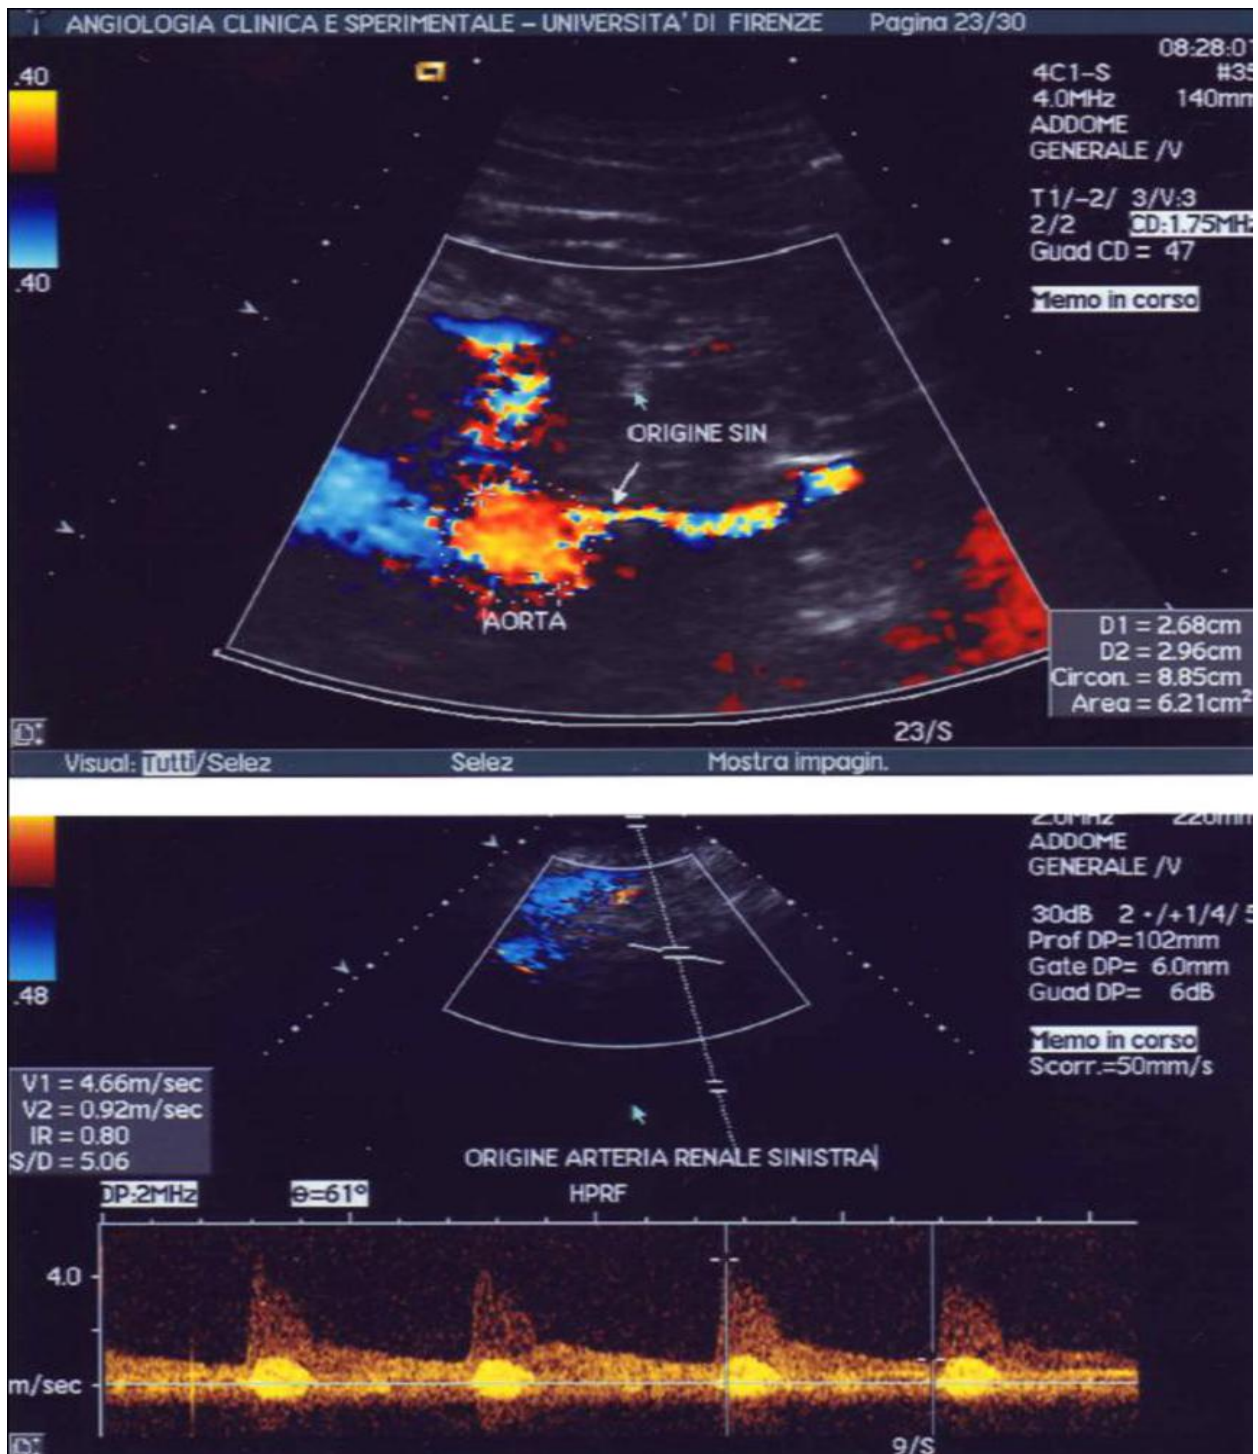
Color and doppler velocity characterization of an hemodynamic stenosis of the left renal artery.
